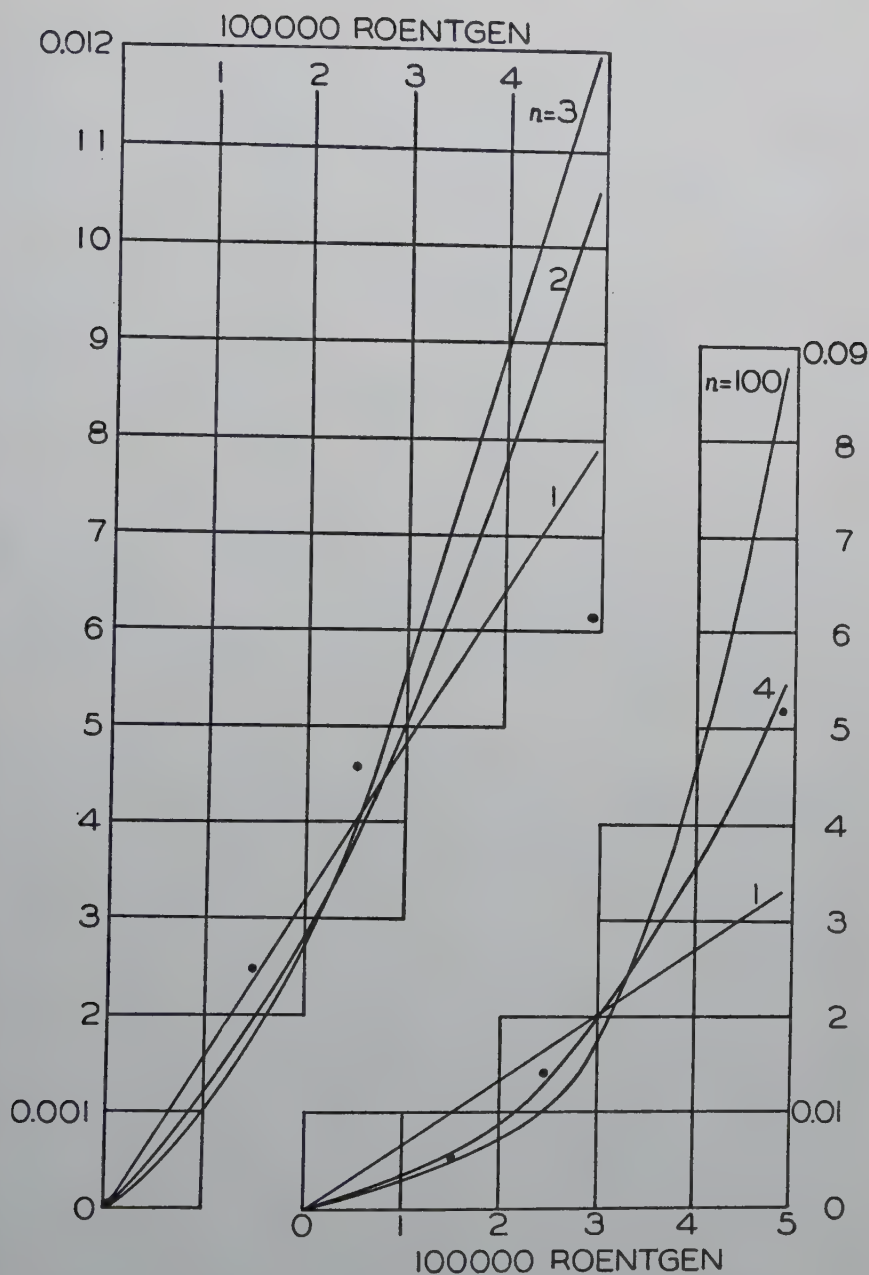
Probability $P(N_D)$ of mutation of the tobacco mosaic virus to *aucuba* against the energy D in roentgen which produces this mutation. Theoretical curves and points computed from the experimental data.
